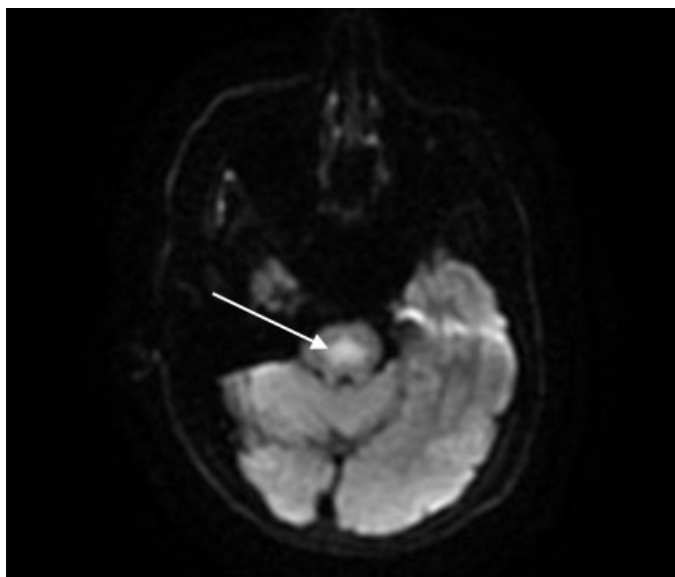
Brain diffusion-weighted magnetic resonance imaging (MRI) performed four days after symptom onset with hyperintense changes delineating a zone of early demyelination within the central pons (arrow).
